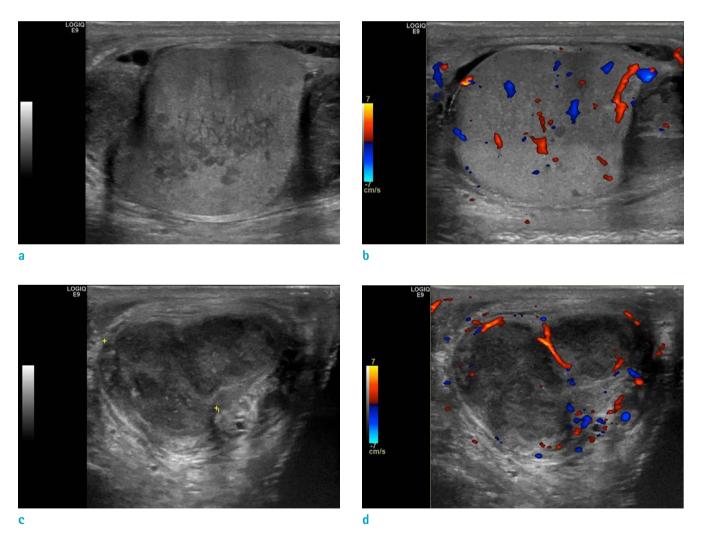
A 22-year-old male with multifocal tuberculosis involving the right scrotum, right sacroiliac joint, right wrist, and lung. (a, b) Gray and color-scale US showed multiple small hypoechoic nodular lesions in the slightly enlarged right testis, with hypervascularity. (c, d) Grayscale US image of the right epididymis showed a nodular, enlarged, and heterogeneously hyperechoic lesion at the right epididymal head and tail, with hypervascular change in color Doppler US.
